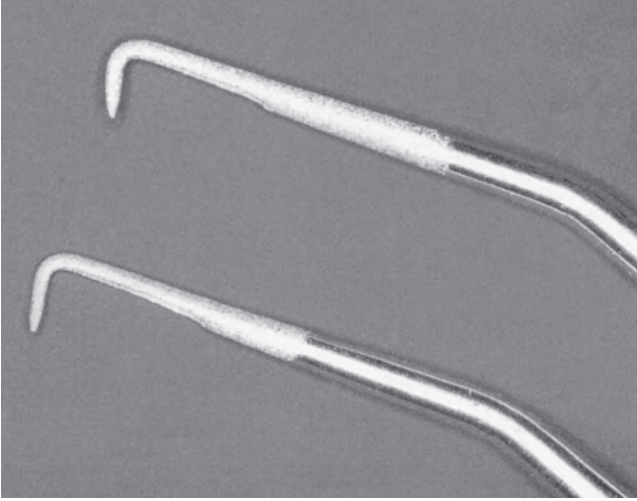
Close-up view of KiS Microsurgical Ultrasonic Instruments (Obtura Spartan). The tips are coated with zirconium nitride for faster ultrasonic cutting and are no more than 3 mm long.
